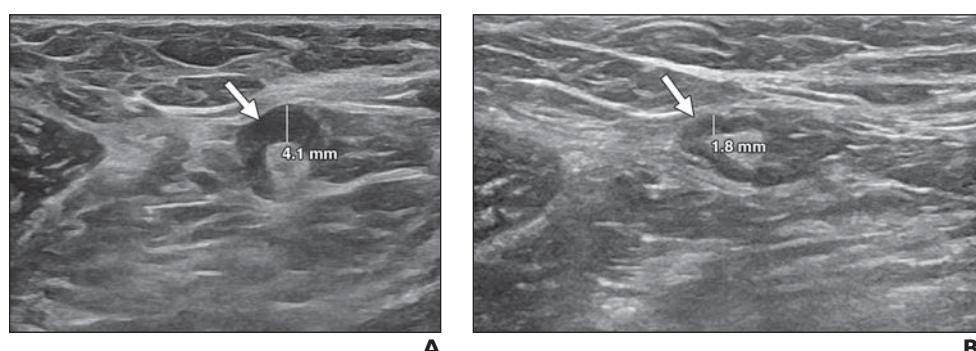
33-year-old woman undergoing bilateral screening breast ultrasound. Example of retrospective lymph node measurements.
